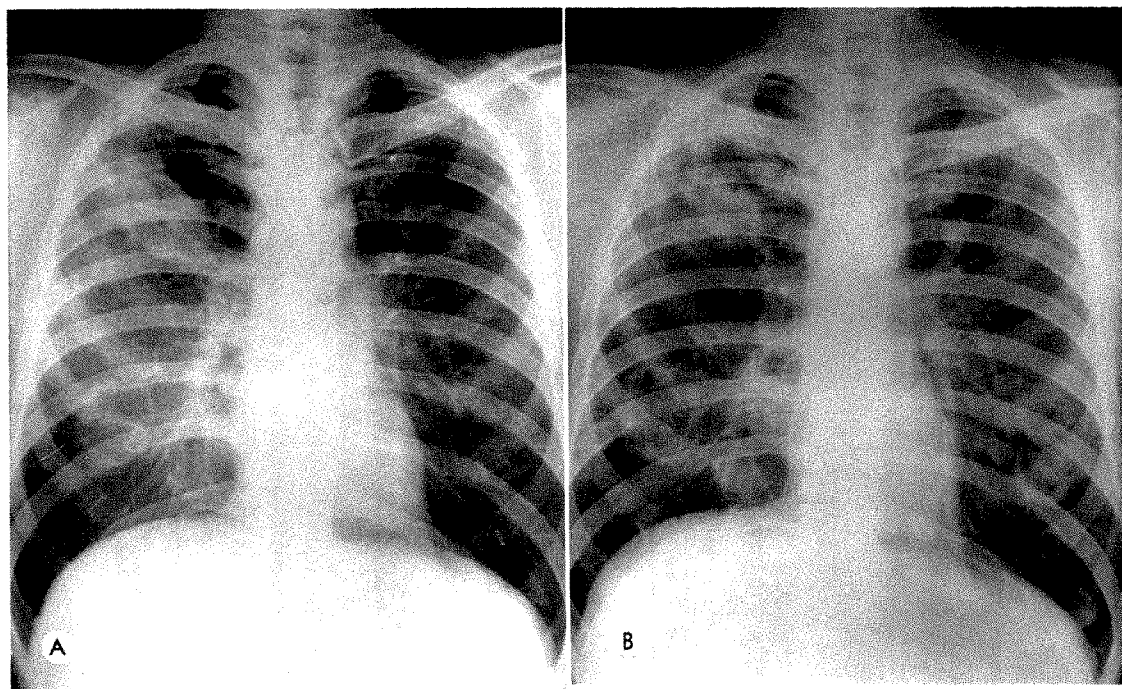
Multiple excavating pulmonary metastases in a forty-six year old white male. Thirty months previously an abdominal-perineal resection had been performed for a well differentiated, nonmucoid adenocarcinoma of the rectum. The pulmonary biopsy of the right upper lobe lesion revealed a well differentiated adenocarcinoma. (Courtesy of Dr. Marjorie Le May, Boston, Massachusetts.) (A) Diffuse inflammatory disease involving cystic metastases of the right upper lobe. Temperature 103° F. The pneumonic process was not present on a roentgenogram made four days previously. (B) Seven-month follow-up roentgenogram. The metastases have increased in size and number, but the cavity walls maintain average thickness. Inflammatory disease has partially obliterated right upper lobe cavities. The large right lower lobe cavity is more irregular, suggesting the presence of intermittent ball-valve mechanism.
